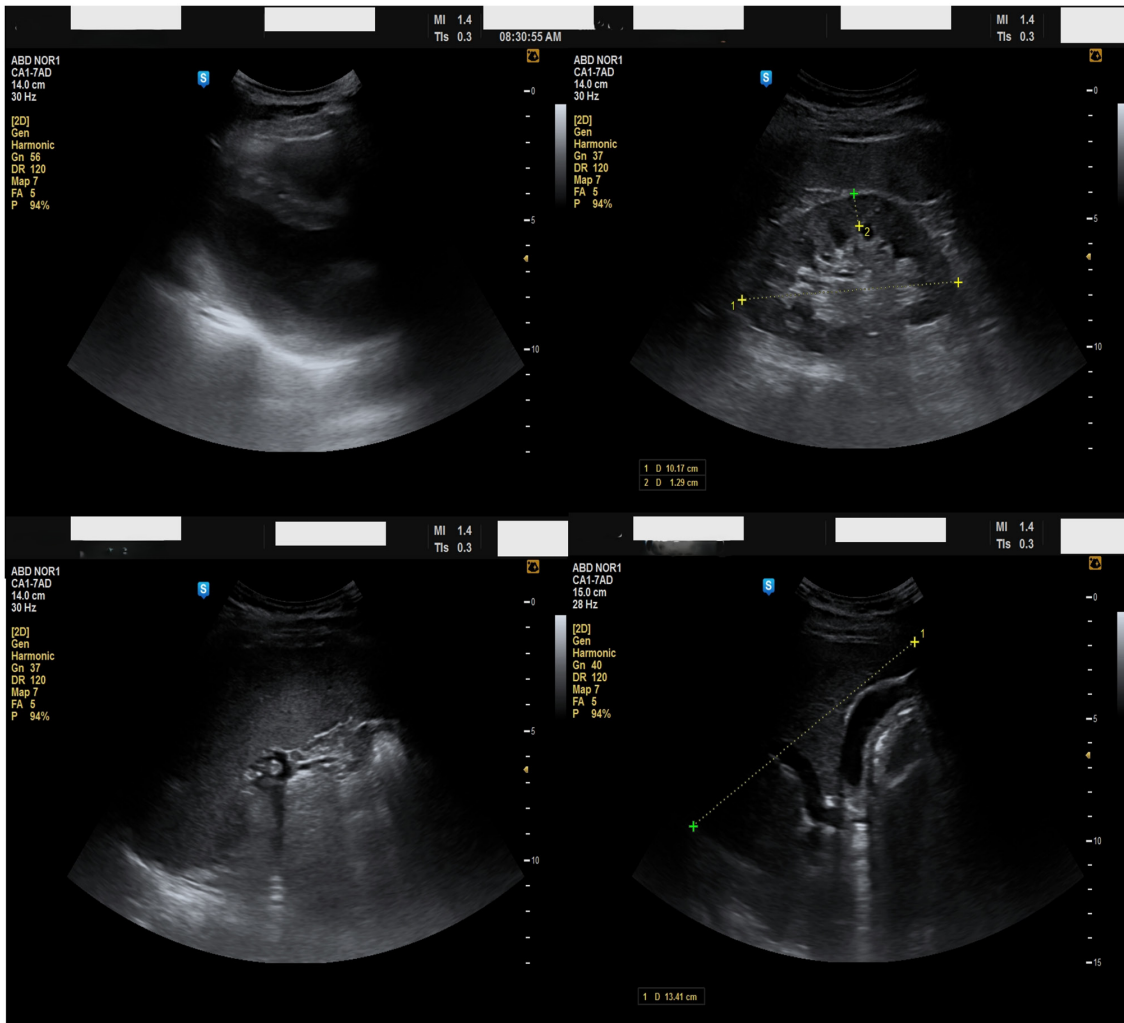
Abdominal ultrasonography showing the spleen in the right hypochondrium.
